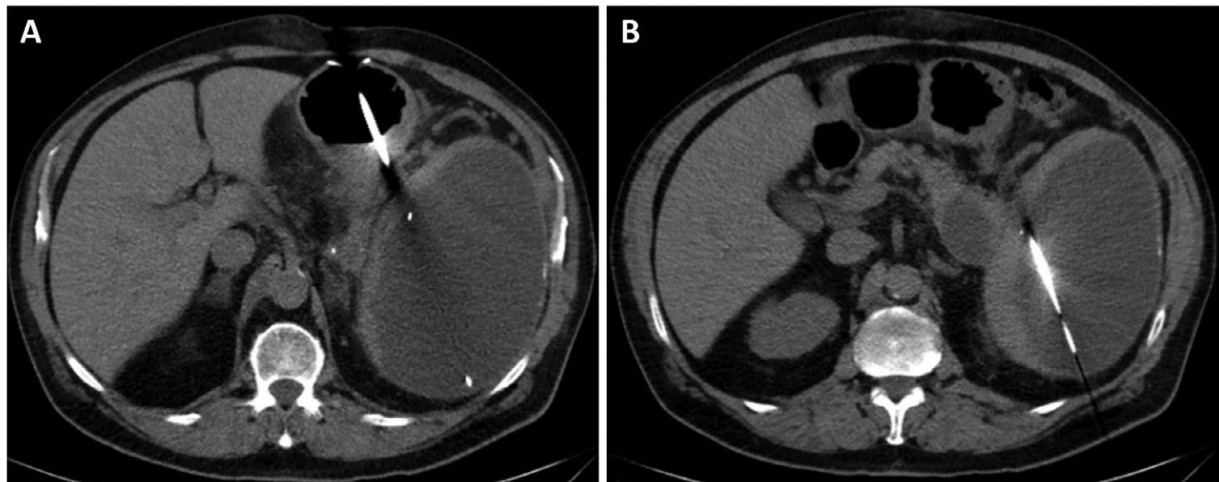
Axial CT scan (A and B) demonstrate successful placement of a 14 French transgastric cystogastrostomy tube with distal pigtail loops within the splenic subcapsular space.
